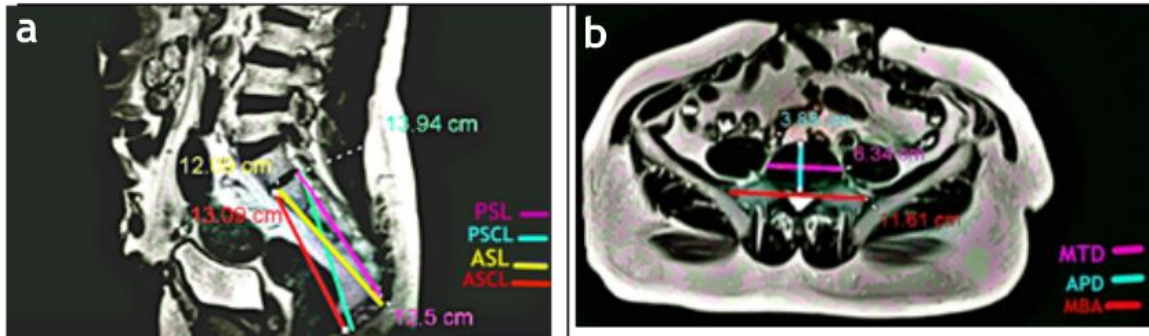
MRI image showing (a): measurements of posterior sacral length (PSL), posterior sacrococcygeal length (PSCL), anterior sacral length (ASL), anterior sacrococcygeal length (ASCL) in the sagittal plane; (b): antero-posterior diameter of S1 vertebra corpus (APD), maximum transverse diameter of S1 vertebra corpus (MTD) and maximum breadth of alae sacralis (MBA) in the axial plane.
